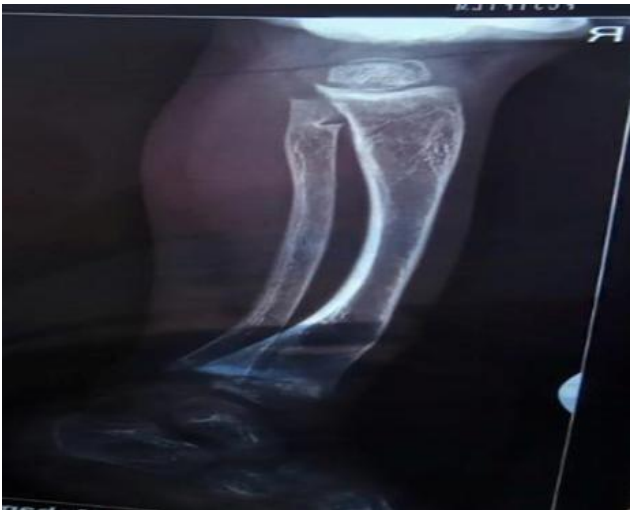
Radiograph of wrist at diagnosis in case 1 showing classical rachitic changes.
